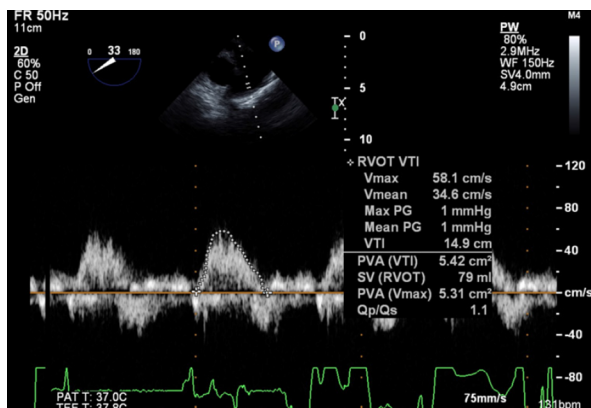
Continuity equation to calculate shunt fraction Qp:Qs using transesophageal echocardiography.
